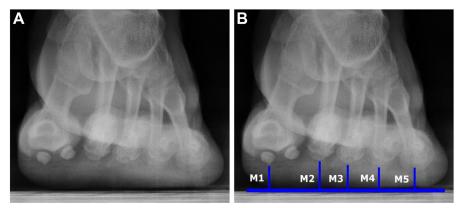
(*A*) Weight-bearing axial X-Ray of the foot—evaluating the coronal plane. (*B*) Metatarsal formula measurements on the coronal plane. The M2 and M3 usually are more distant from the ground than M1, M4, and M5. These parameters must be observed for diagnosis, planning, and surgical intervention.
